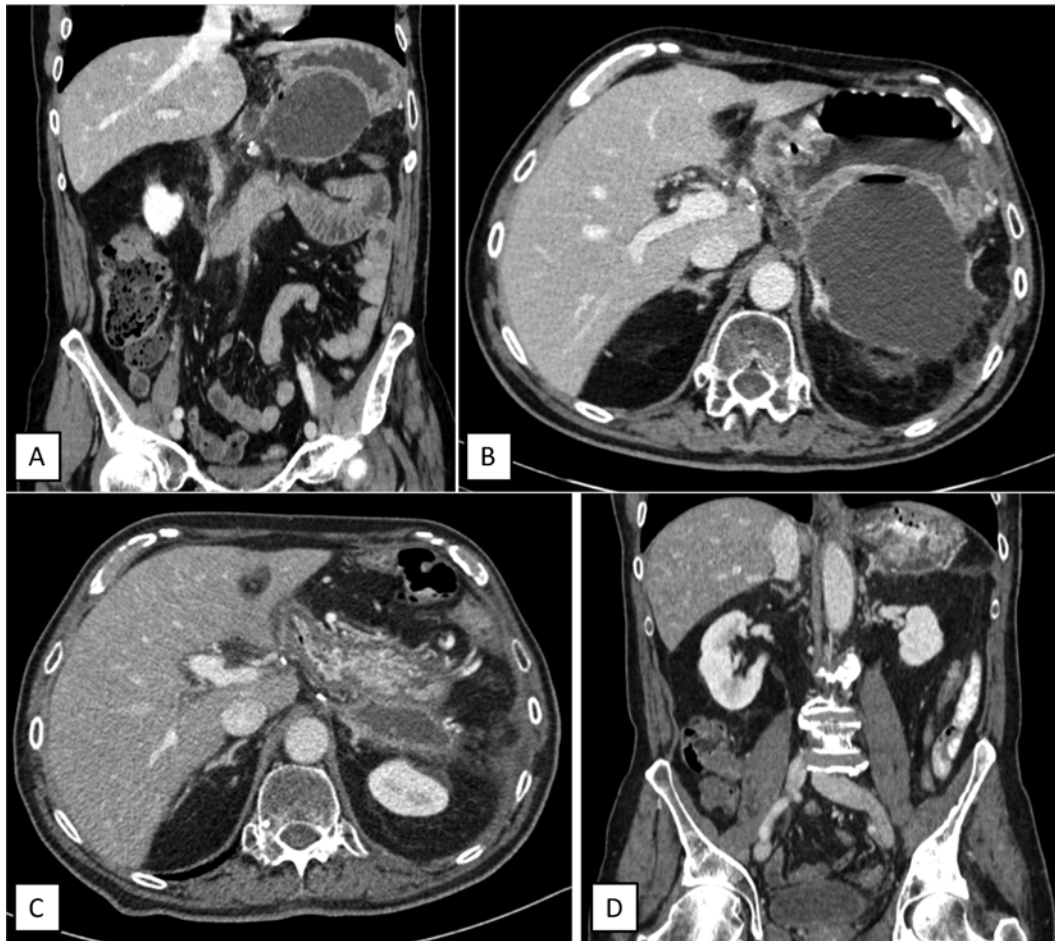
Post-operative scheduled CT scan showing retrogastric collection (A: Coronal view. B: Cross-section showing posterior gastric wall thinning) and control CT scan after completing endoluminal vacuum-assisted therapy, showing decrease in collection size, without defects on the gastric wall (C: Cross-sectional view. D: Coronal view).
